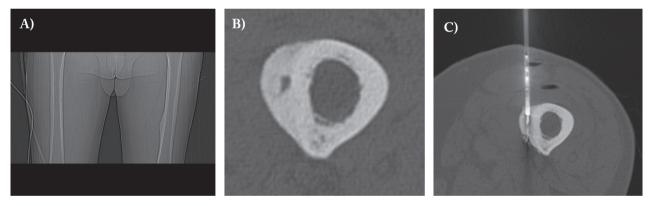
Osteoid osteoma of the femur in elderly patient. 71 year old male with unremittent left thigh pain; osteoid osteoma was not clinically suspected, since it is quite uncommon in this age range. (A) CT scanogram demonstrating the presence of focal cortical thickening of the left femoral diaphysis. (B) Classical CT appearance of osteoid osteoma: central radiolucent *nidus* surrounded by sclerotic reactive bone. (C) Radiofrequency ablation was effective in achieving complete resolution of the symptoms
